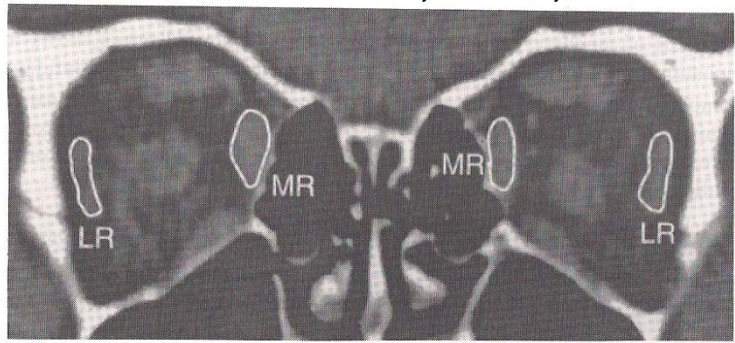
211  $\mu$ m resolution, 1 mm thick coronal CT scan of the orbits of a 5 year old girl with large "V" esotropia and marked overelevation and underdepression of the right eye in adduction. Note inferior displacement of right LR more than left LR.
